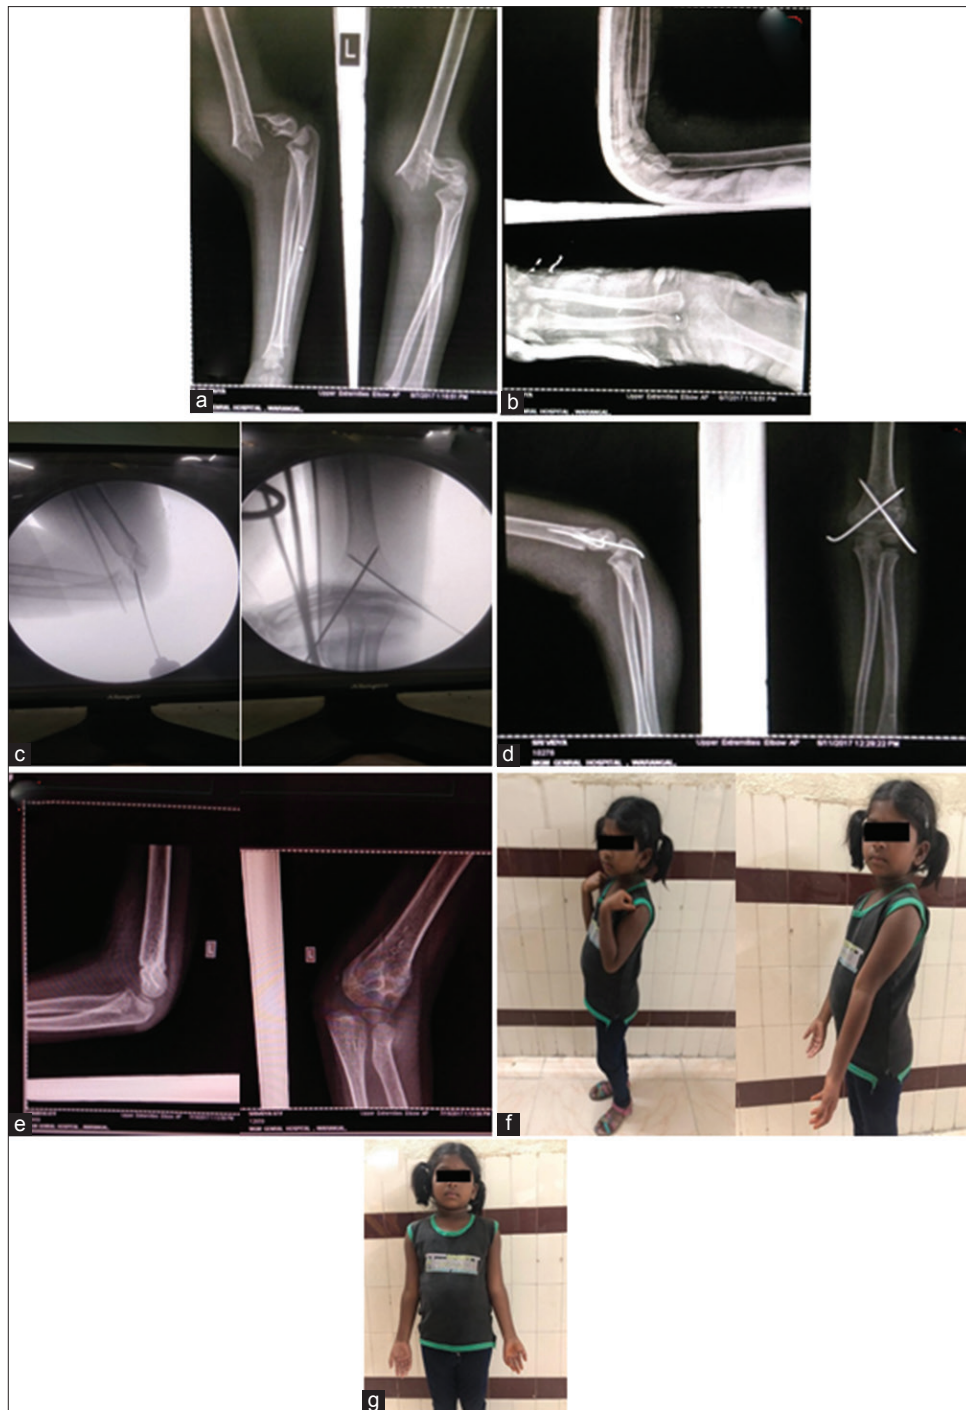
(a) X-ray of the elbow anteroposterior and lateral view showing supra condylar fracture of humerus. (b) X-ray showing immediate splinting of supracondylar fracture of humerus. (c) Intraoperative fluoroscopic images showing fracture fixation with K-wires. (d) Post-operative X-ray showing fracture fixation with K-wires. (e) Late post-operative follow-up X-rays showing evidence of fracture union. (f) Clinical pictures showing functional results during follow-up period: Flexion and extension movements at elbow, respectively. (g) Clinical picture showing carrying angle at elbow during follow-up
